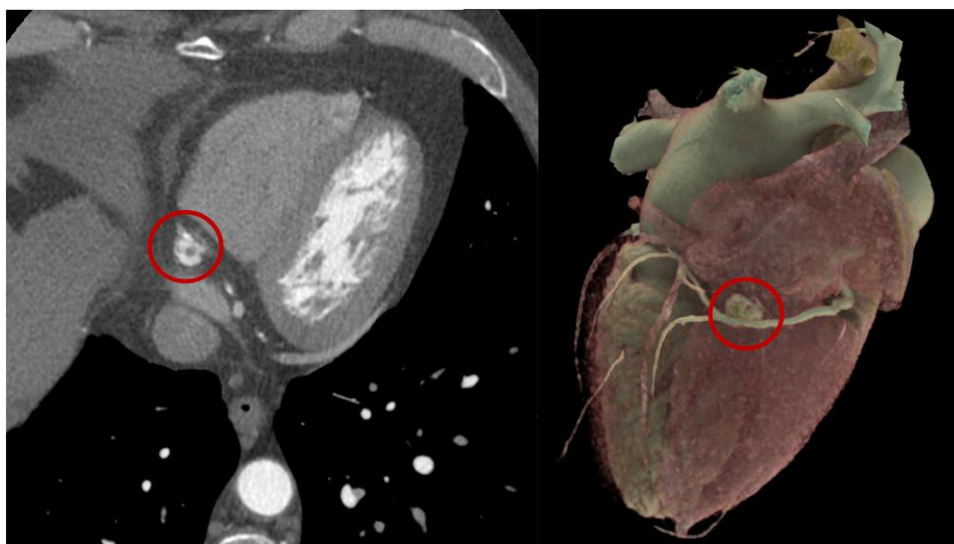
The image on the left shows a transverse section view of the cardiac CT, depicting the largest PGL located in the distal segment of the right coronary artery (indicated by the circle). On the right, a volumetric reconstruction is displayed.
